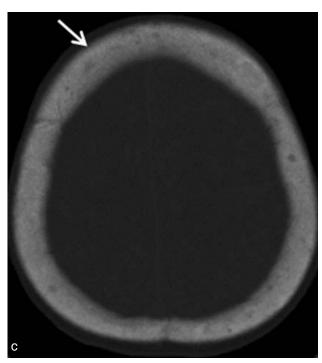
Axial (a,c) and coronal (b) maxillofacial CT images shows bilateral mandibular and maxillary lesions with radiolucent cystic appearance. Note the sclerotic periheral rims (a,b, white arrows) and central sclerotic lineer components (a, white arrow heads). The left maxillary sinus lesion extending through the nasal cavity (red arrow) and pterygopalatine fossa (red arrow head). The expansion of the left maxillary sinus and the left masticator space are visible. The mottled appearance of the calvarium is visible (c, white arrow).
